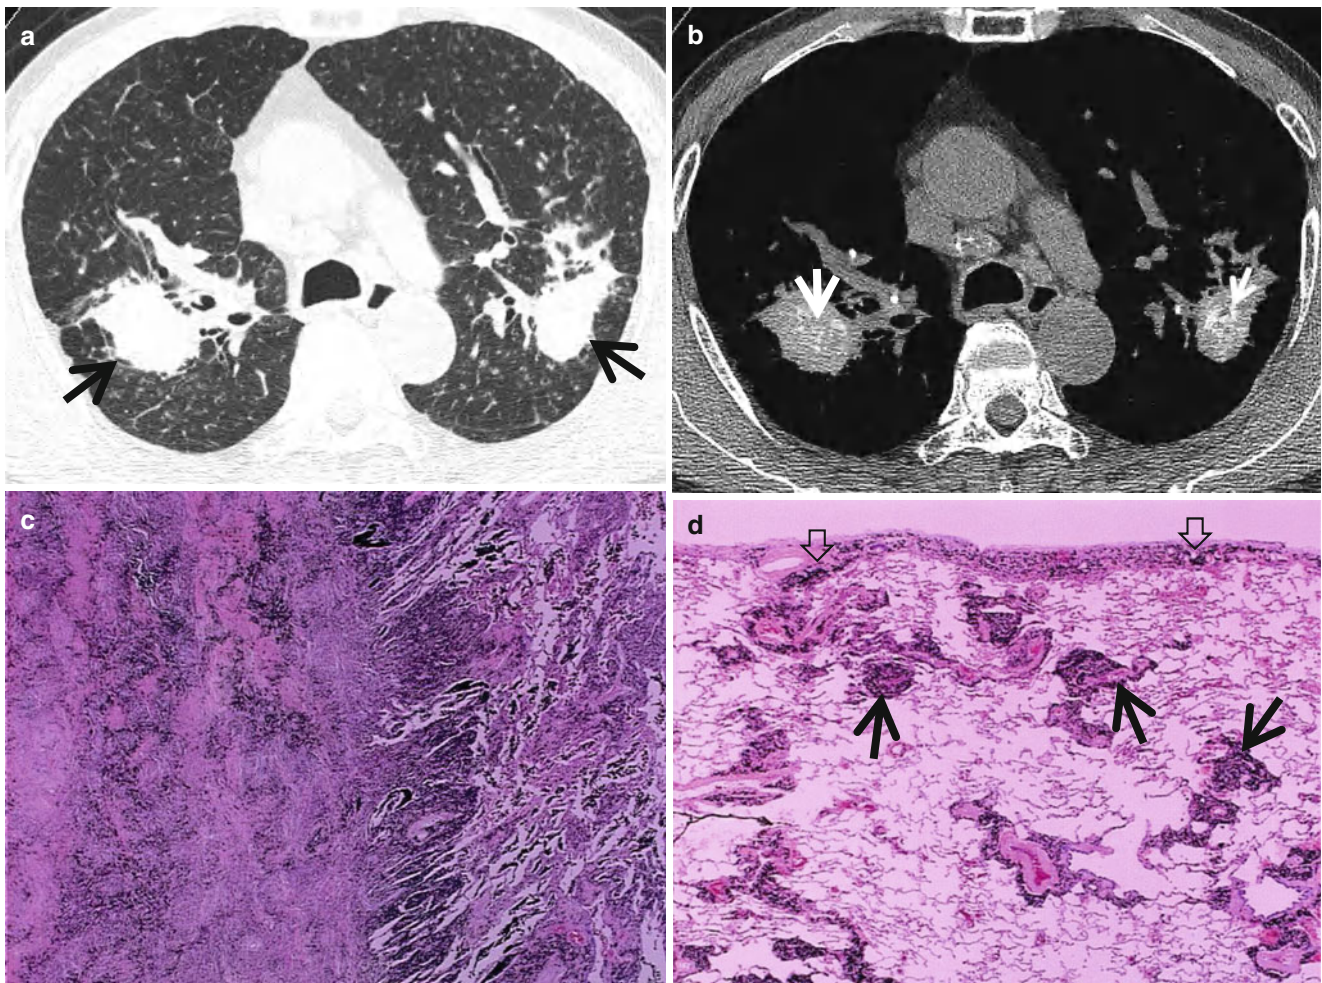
Lung masses as progressive mass fibrosis in a 73-year-old man. (a) Lung window of thin-section (1.5-mm section thickness) CT scan obtained at level of the azygos arch shows two masses (*arrows*) in posterior aspect of both upper lobes. Also note small nodules in both lungs. Combined findings of two large masses and surrounding small nodules in upper lung zones are suggestive of progressive massive fibrosis and pneumoconiotic small nodules. (b) Mediastinal window image demonstrates internal calcifications (*arrows*) within progressive massive fibrosis. Also
